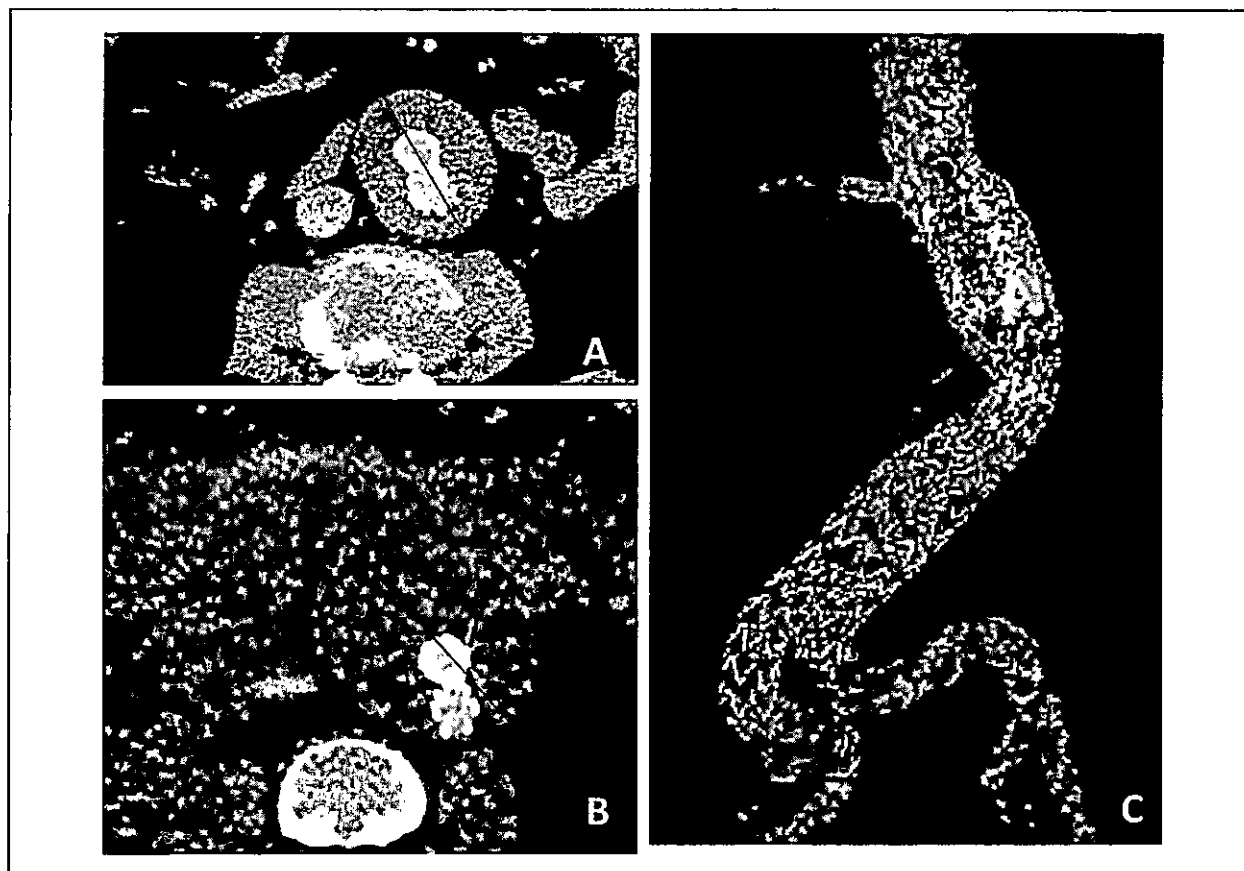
Patients N 4: CT scan shows abdominal aortic aneurysm sac with a diameter of 57 mm in October 2019 (A) and sudden increase of diameter (80 mm) in April 2020, (B) during admission for severe COVID-19 infection. The patient underwent immediate endovascular proximal aortic cuff placement with a double chimney (right renal and superior mesenteric arteries; the left renal artery was chronically occluded), (C): control CT scan control 12 months from surgery. CT, computerized tomography.
